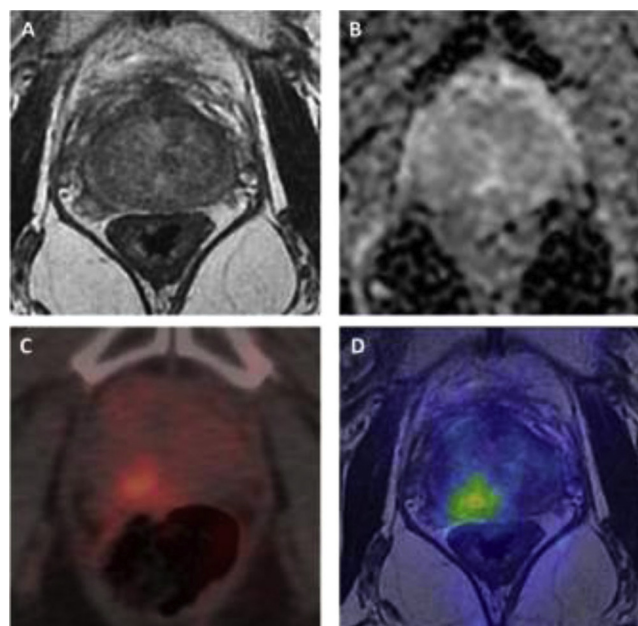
A 64-year-old patient with prostate adenocarcinoma, Gleason 7 (3+4), treated with radiotherapy and 6 months of hormone therapy. The PSA nadir was 0.1 ng/mL. Seven years after treatment, the patient developed a progressive increase in PSA, with a current PSA of 3 ng/mL. Prostate MRI was negative for tumour recurrence and ^{68}Ga -PSMA PET/CT was performed. (A) Axial T2-weighted FSE prostate MRI. The prostate shows a marked hyposignal secondary to treatment without evidence of nodular lesions. (B) Prostate MRI with ADC mapping with a b-value of 1400s/mm² with no diffusion restriction. (C) Axial ^{68}Ga -PSMA PET/CT image and (D) ^{68}Ga -PSMA PET/MRI co-registered image. A nodule located in the posterior peripheral area of the right lobe of the prostate with PSMA overexpression.
